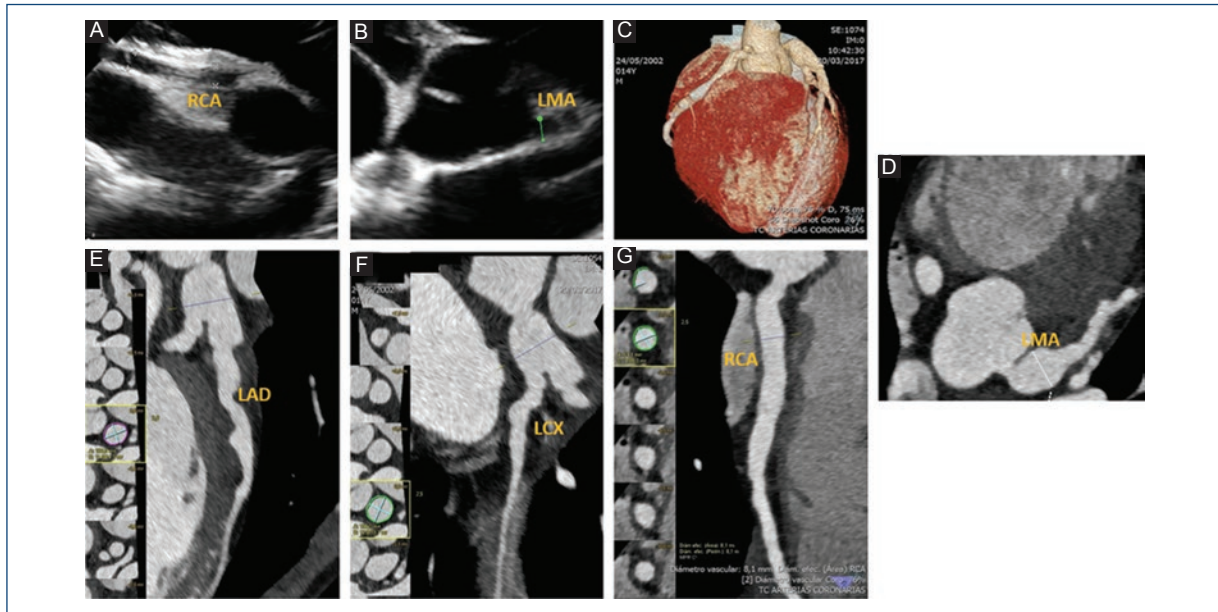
(A-G) Coronary aneurysms. (A) Transthoracic echocardiography (TTE) demonstrating dilation of the right coronary artery; RCA: right coronary artery. (B) TTE demonstrating dilation of the left main artery; LMA: left main artery. (C-G) Coronary computed tomography confirming the presence of large coronary aneurysms; LAD: left anterior descending artery; LCX: left circumflex artery.
